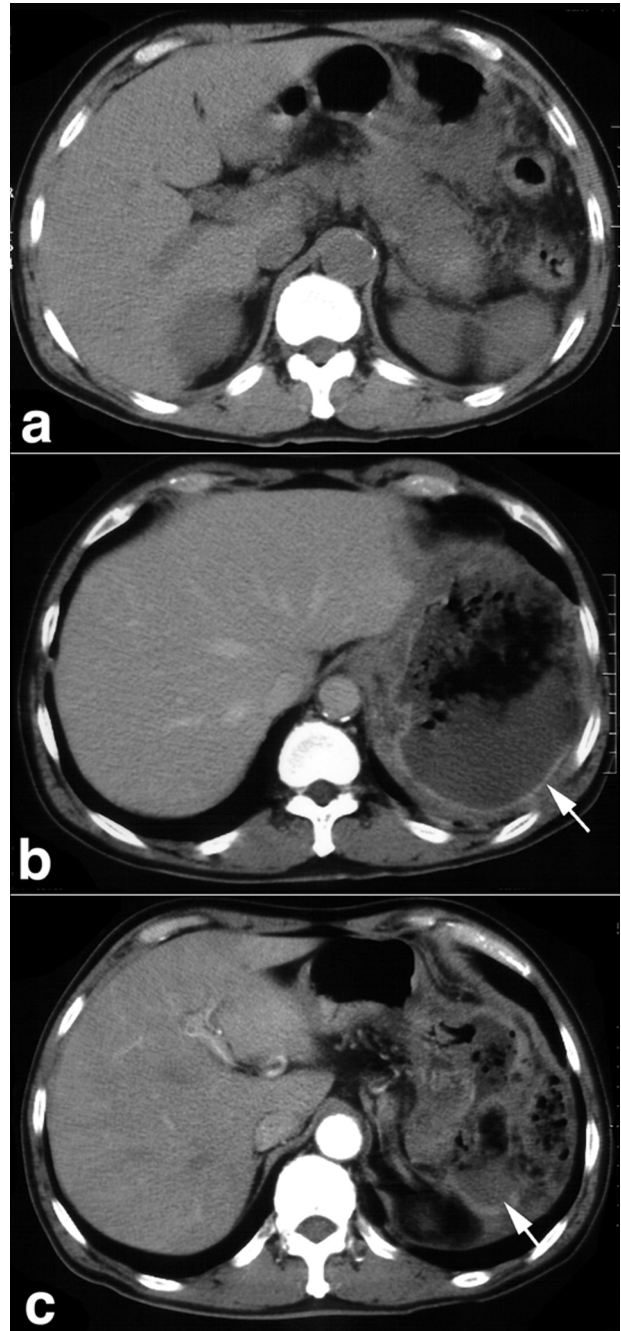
(a) Abdominal computed tomography (CT) of the patient on admission revealed swelling of the pancreas and fluid accumulation in the anterior parapancreatic space. (b) Abdominal enhanced CT on the 29th day. The spleen was not enhanced in the least (arrow), which showed whole splenic infarction. (c) Abdominal enhanced CT on the 57th day showed a quite atrophic spleen (arrow) that could not be differentiated from the stomach.
